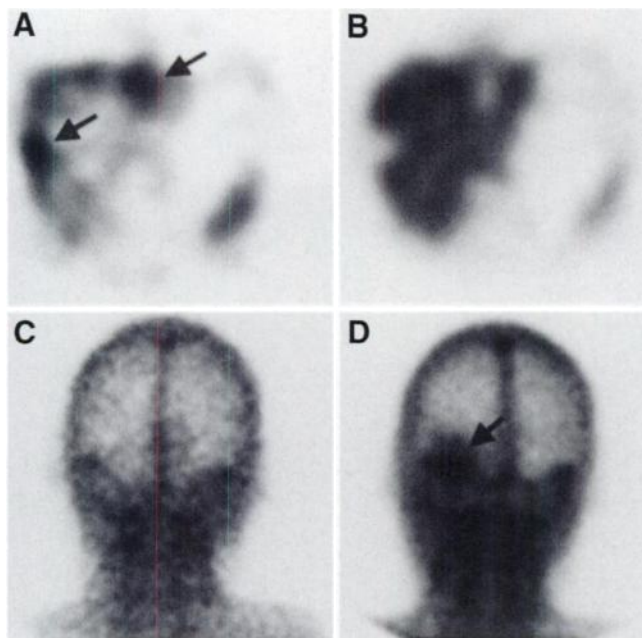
Arcitumomab images obtained 5 mo apart of colorectal patient with extensive liver involvement. Transverse SPECT images of liver initially show increased focal uptake at sites of metastases (arrows, A) but show decreased uptake after treatment by infusional ethanol ablation (B). Posterior planar images of head show normal findings initially (C) but disease progression on repeated study involving left occipital and parietal scalp (arrow, D).
